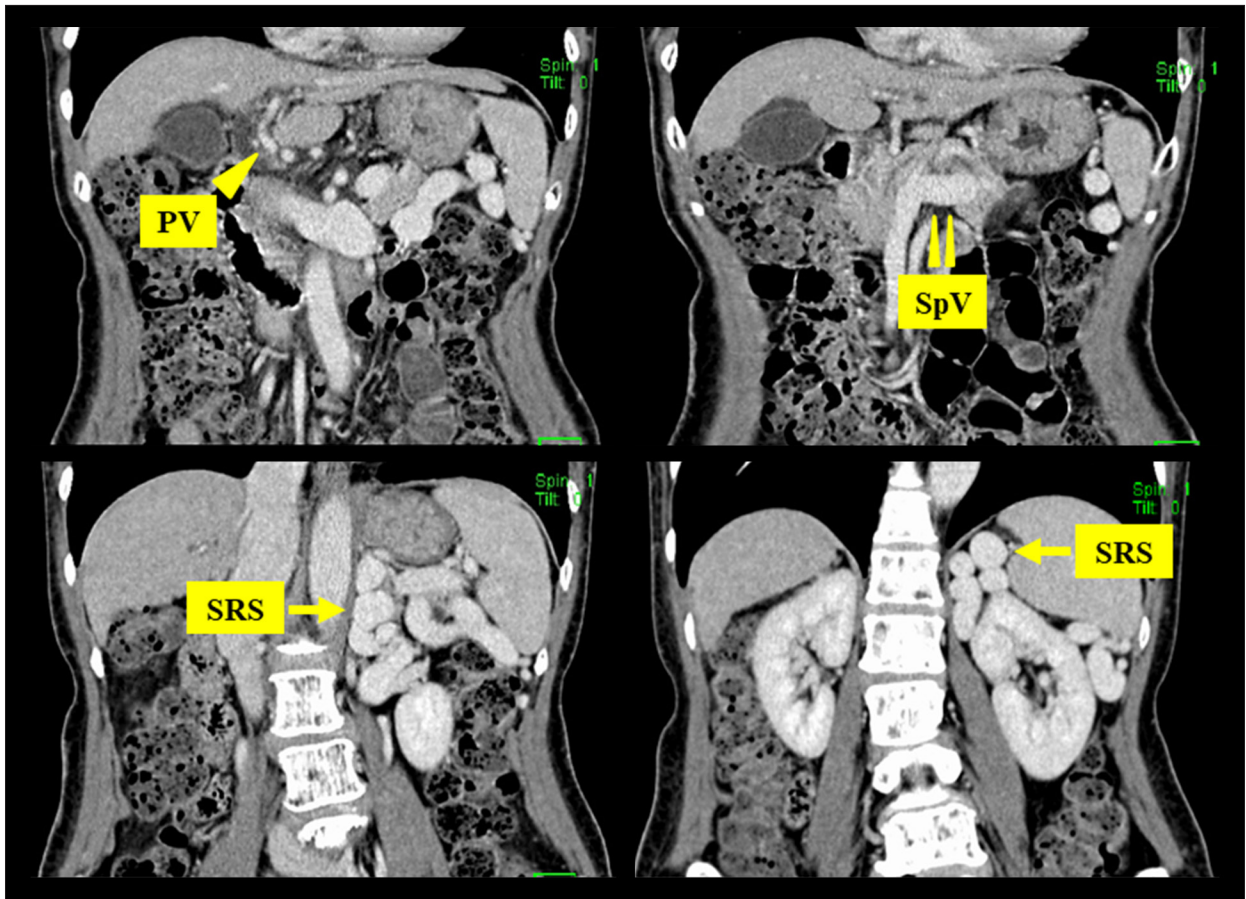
CE-CT before BRTO. Pre-BRTO CE-CT revealed significant liver atrophy (434.7 cm^3), severe portal vein constriction (6.2 mm), severe splenic vein dilation (14.2 mm), and the development of a giant splenorenal shunt (20.1 mm). CE-CT – contrast-enhanced computed tomography; BRTO – balloon-occluded retrograde transvenous obliteration; PV – portal vein; SpV – splenic vein; SRS – splenorenal shunt.
